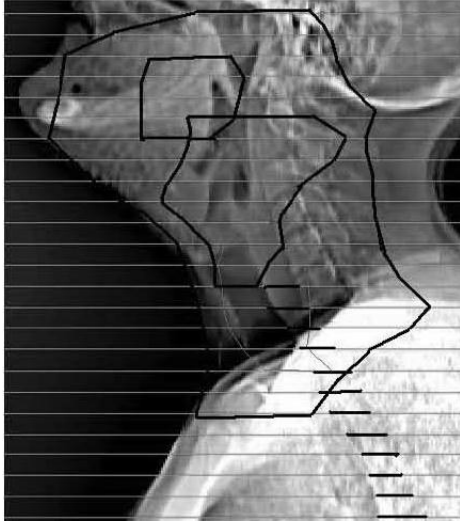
Delineation of the whole esophagus in the CT scan of a patient with 1 cm distance of the slices. Except from the esophagus, the PTV, the CTV and the tumor are contoured.
